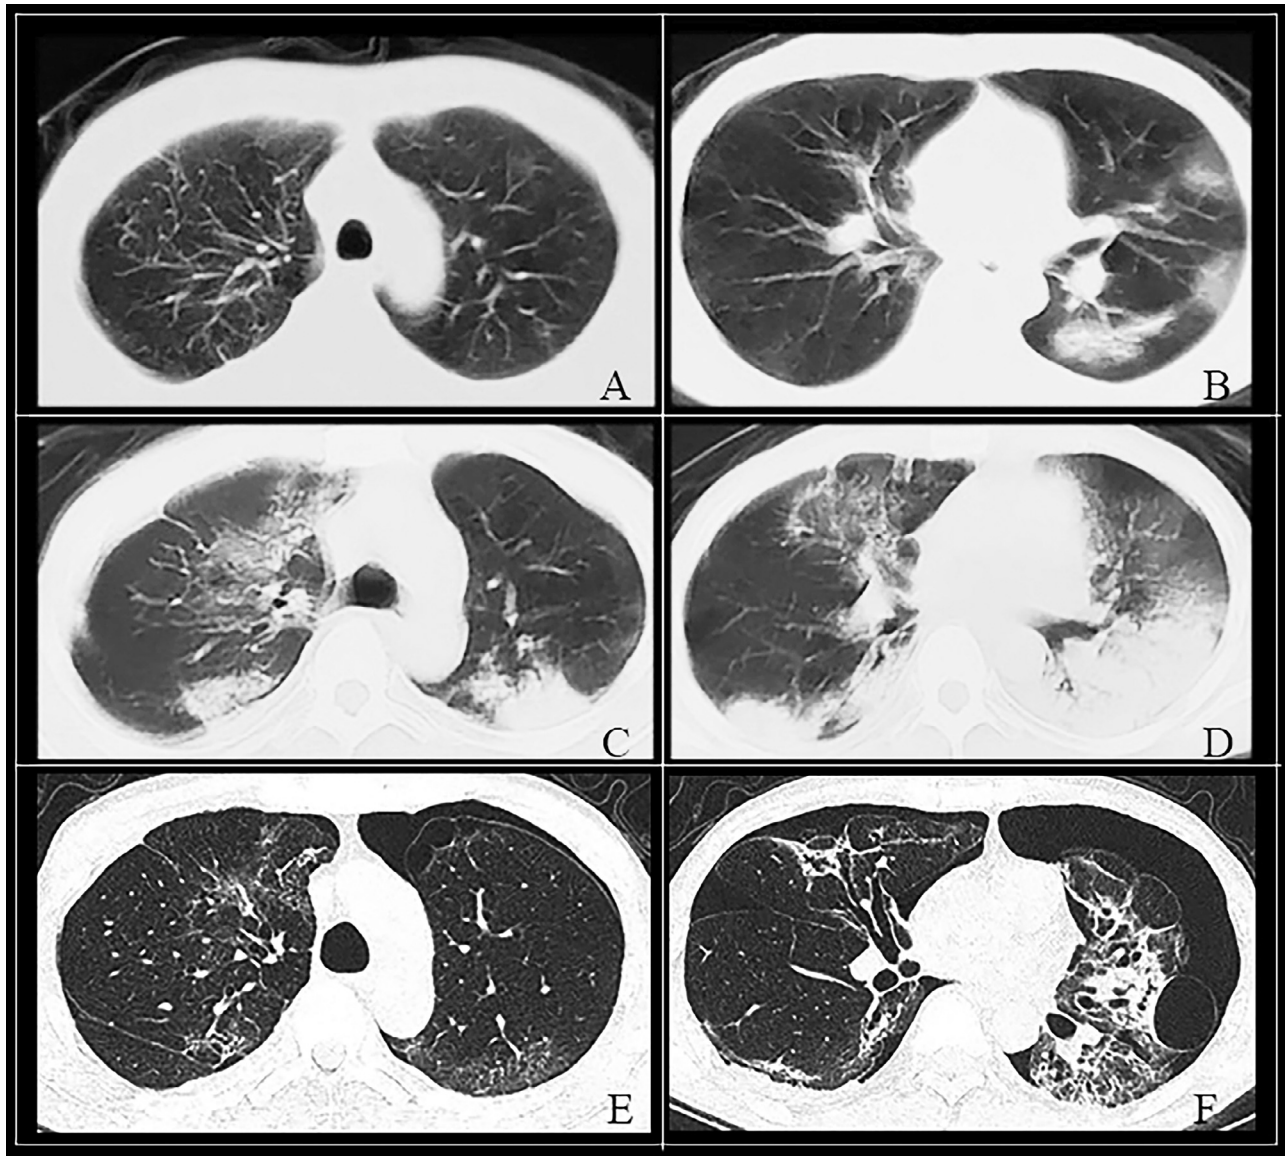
Chest CT images of a 48-year-old man with COVID-19. (A-B) Initial CT images showed multiple ground-glass opacities (GGOs) in peripheral area in bilateral lungs. (C-D) Images obtained on day 15 showed that GGOs increased in extent and density, progressing into multiple consolidations. (E-F) On day 45, parts of GGOs and consolidations transformed into emphysema and giant bulla, and bilateral pneumothorax were also observed.
